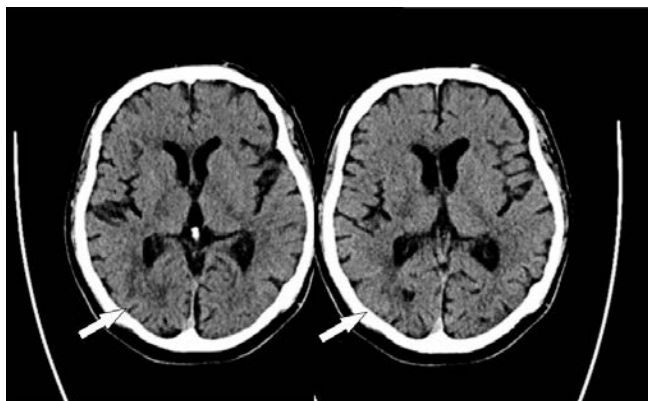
CT, tumour infiltration in right occipital lobe (arrow) that later was confirmed as DLBCL
